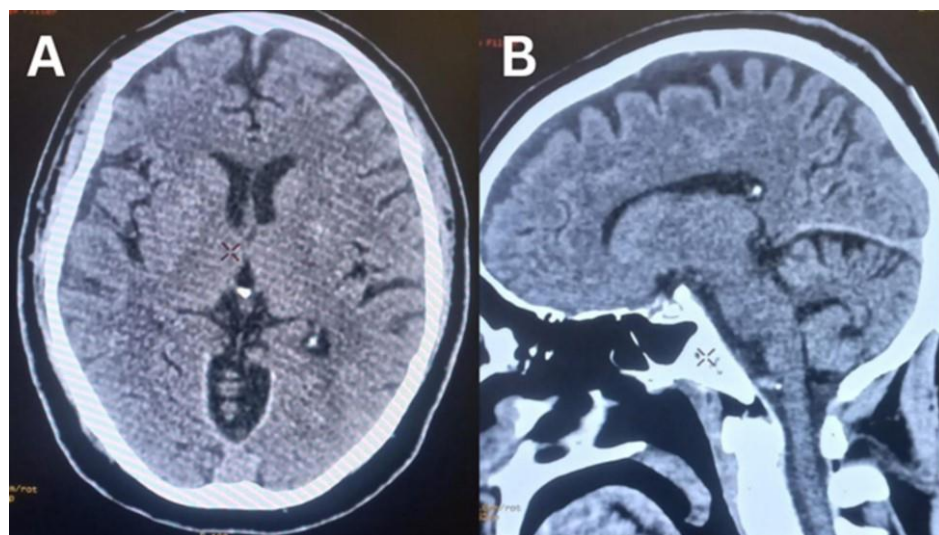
CT Scan Brain (A) Axial View, (B) Sagittal View.
